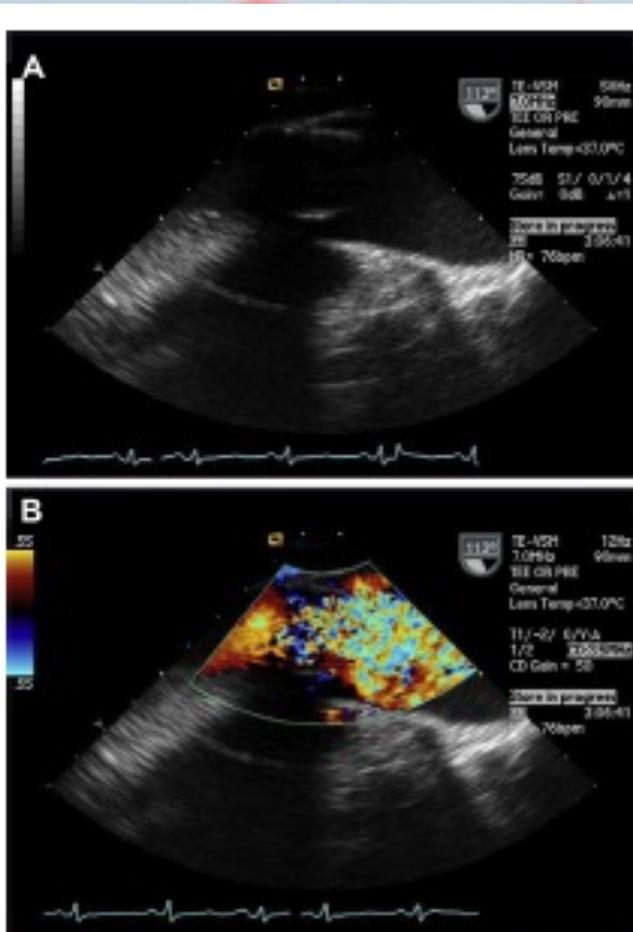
Transesophageal echocardiographic long-axis view with zoom of the aortic valve showing a dilated ascending aorta but no obvious leaflet abnormalities (A). Significant color flow acceleration across the bioprosthetic aortic valve is seen (B). After aortotomy and removal of the bioprosthesis, extensive
